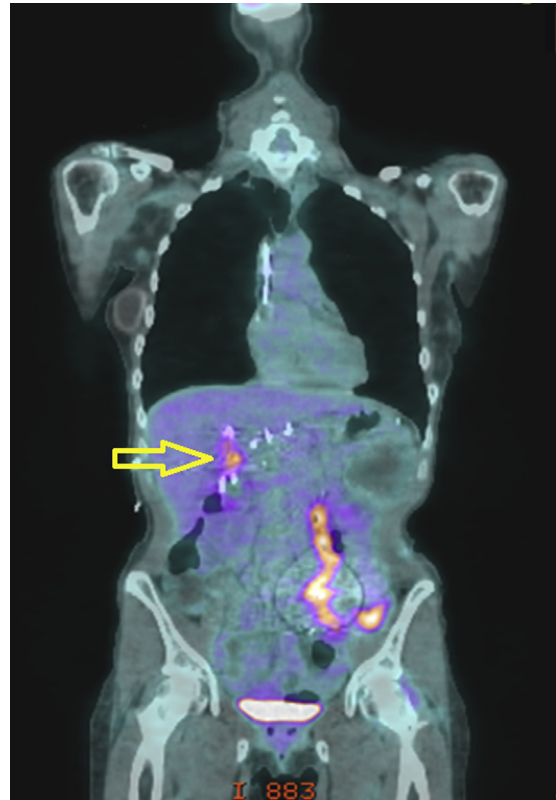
Positron emission tomography/CT scan showing obvious uptake in the hepatic hilum (*yellow arrow*) but no other abnormalities.
